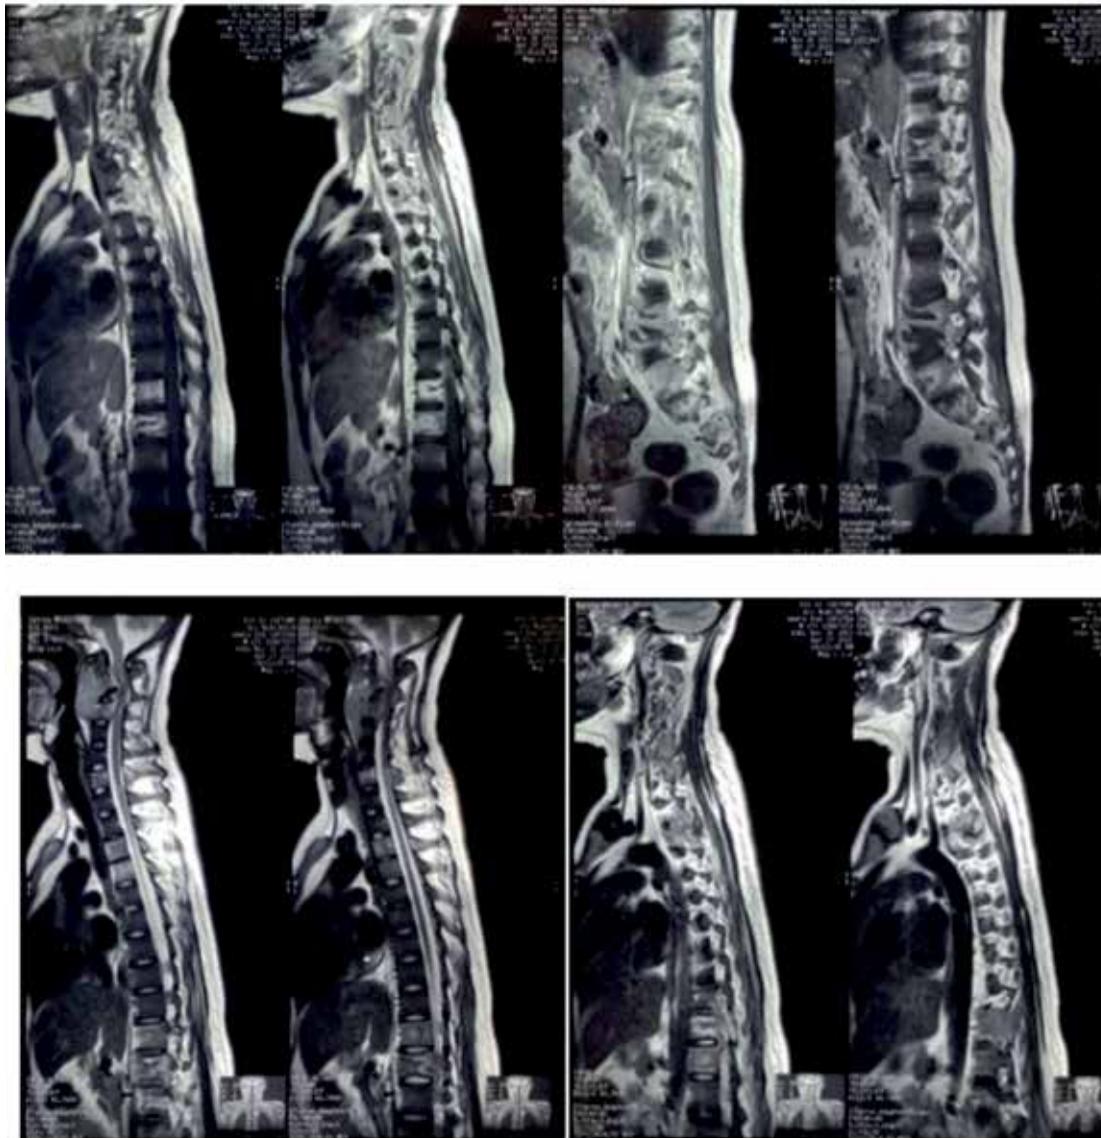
MRI examination of the whole spine showing destruction of corpus vertebrae at C2-C4, C7, T2-T3, T9-T10, and L3-L5 level with intraosseous abscess and paravertebral soft tissue mass that extends to the epidural causing severe spinal cord compression
